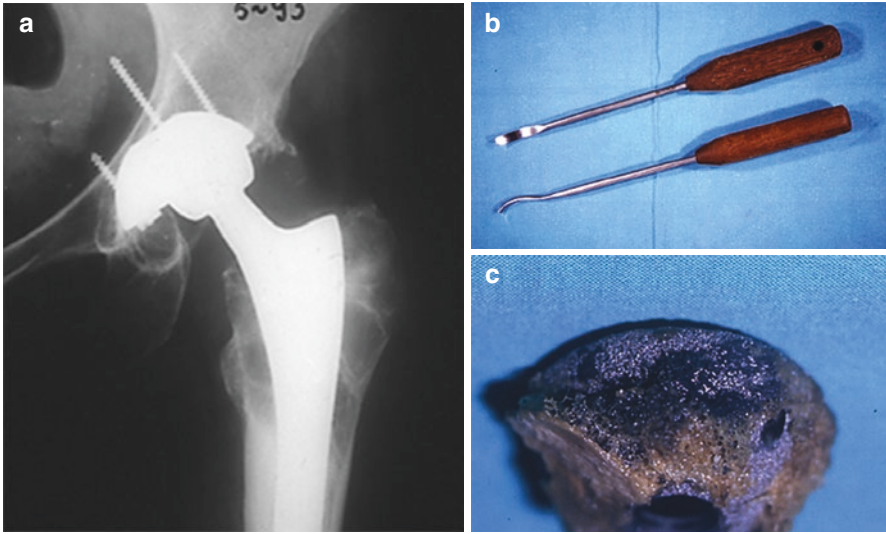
(a) Anteroposterior radiograph of a 74-year-old man twelve years postsurgery shows a stable cup with severe polyethylene wear. (b) Curve osteotomes were used in a circumferential manner to disrupt the bone-implant interface. (c) Photograph shows the removed host bone with the acetabular socket increasing the preoperative bone defect
